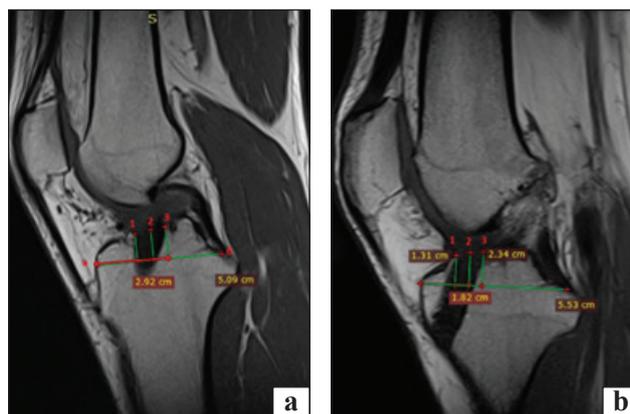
Measurement of the point of entry of the tibial canal on the sagittal projection of MRI visualization. a–b is the Amis and Jacob line. 1 — the point of the anterior edge of the tibial canal, 2 — the point of the middle of the tibial canal, 3 — the point of the posterior edge of the tibial canal. In the image, the location of the canal is within: 33–57%, the middle is 46 % of the entire anterior-posterior distance of the plateau, and is within acceptable limits (a); 24–42 %, midpoint 33 % of the entire anterior-posterior distance of the plateau, and is too anterior. The graft is absent (b)
